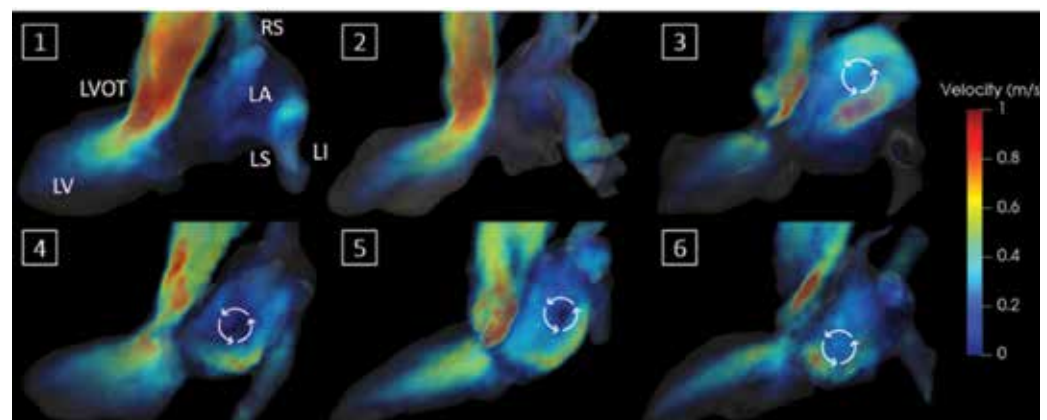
Volumetric rendering of the 4D flow MRI velocity fields mid-systole, including arrows pointing in the direction of the blood flow. A clear LVOT obstruction can be observed in patients 3-6 caused by systolic anterior motion. The distinctive rotational flow pattern in the LA is a consequence of the mitral regurgitation jet.
